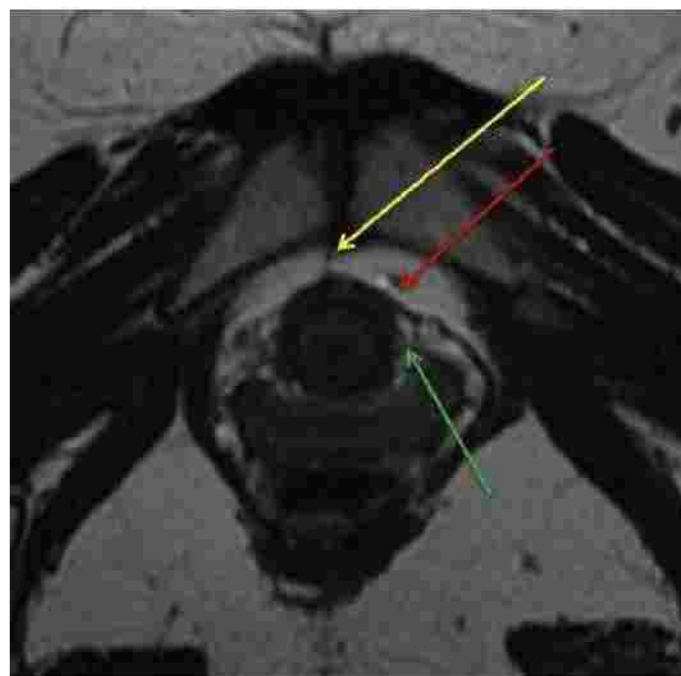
Normal urethral supporting ligaments. Axial T2-weighted MR image shows pubourethral ligament (yellow arrow), periurethral ligament (green arrow), and paraurethral ligament (red arrow).
